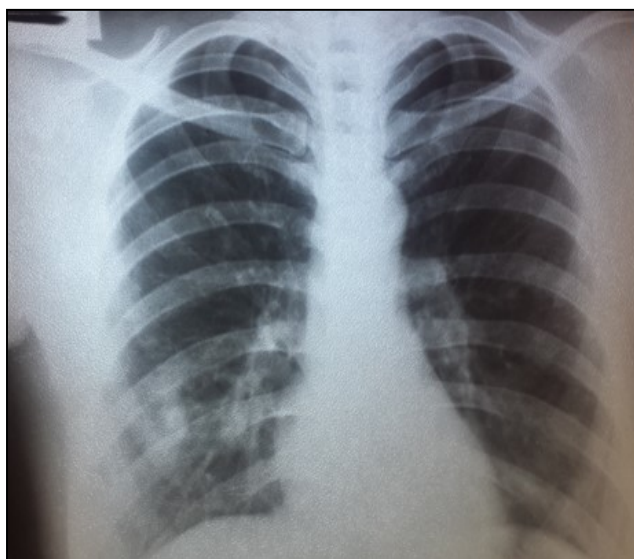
Initial chest radiograph showing right lower lung zone opacity.
